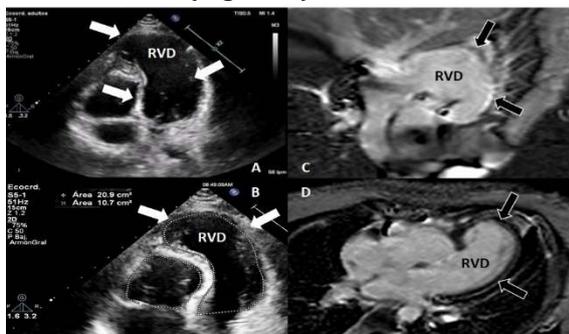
Echocardiographic images in 4 chambers projection (A, B) and Magnetic Resonance (B, C) that show a Right Ventricle Dilated (RVD); absence of myocardial tissue in apex, thinning and fibrosis in lateral wall (Arrows)
